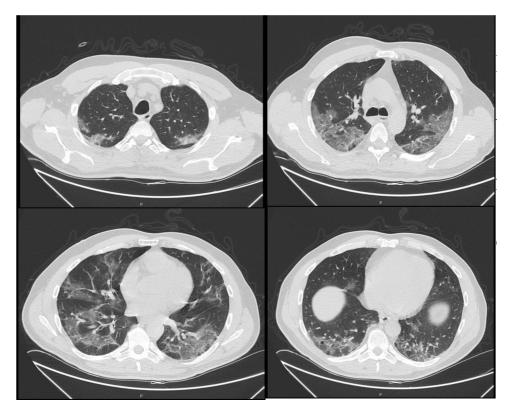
CT-scan. Bilateral consolidations with ground-glass areas, mainly in the posterior dependent zones.
